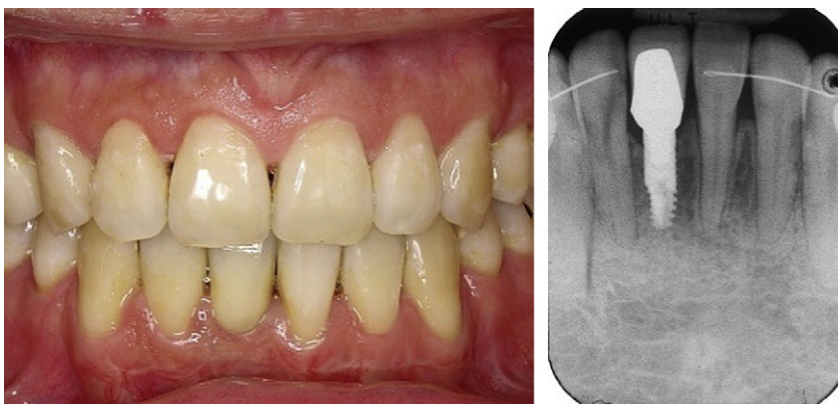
The three-year follow-up (left) and periapical film (right).
